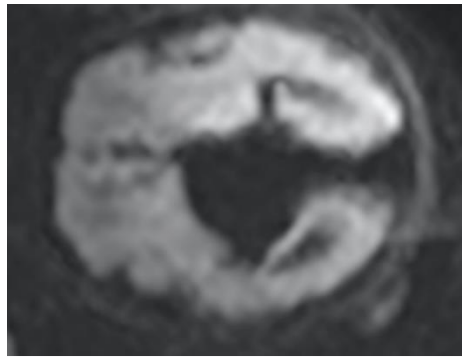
Diffusion-weighted imaging (DWI) shows no ischemic signal in the brain parenchyma, and the mass was a low signal indicating no thrombus and hemorrhage.
